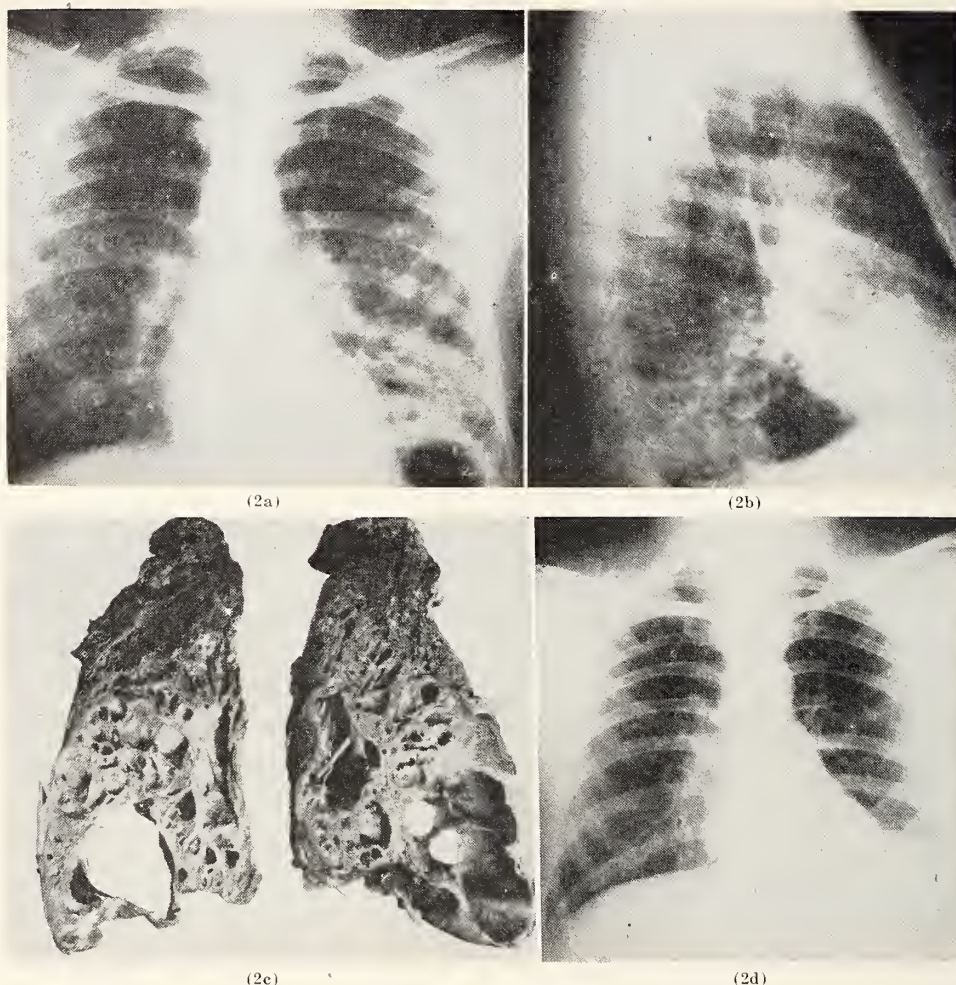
(Case No. 2) (a and b) Front and lateral views of x-rays of the chest following iodized oil injection. Note numerous cystic spaces in left lower lobe. (c). Photograph of two slices of lobe removed. (d). Postoperative appearance of chest.
